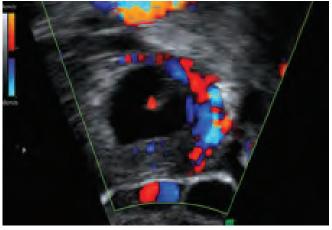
Prominent blood flow signals indicate vital trophoblast. In addition to peritrophoblastic flow, color Doppler can depict embryonic cardiac activity
